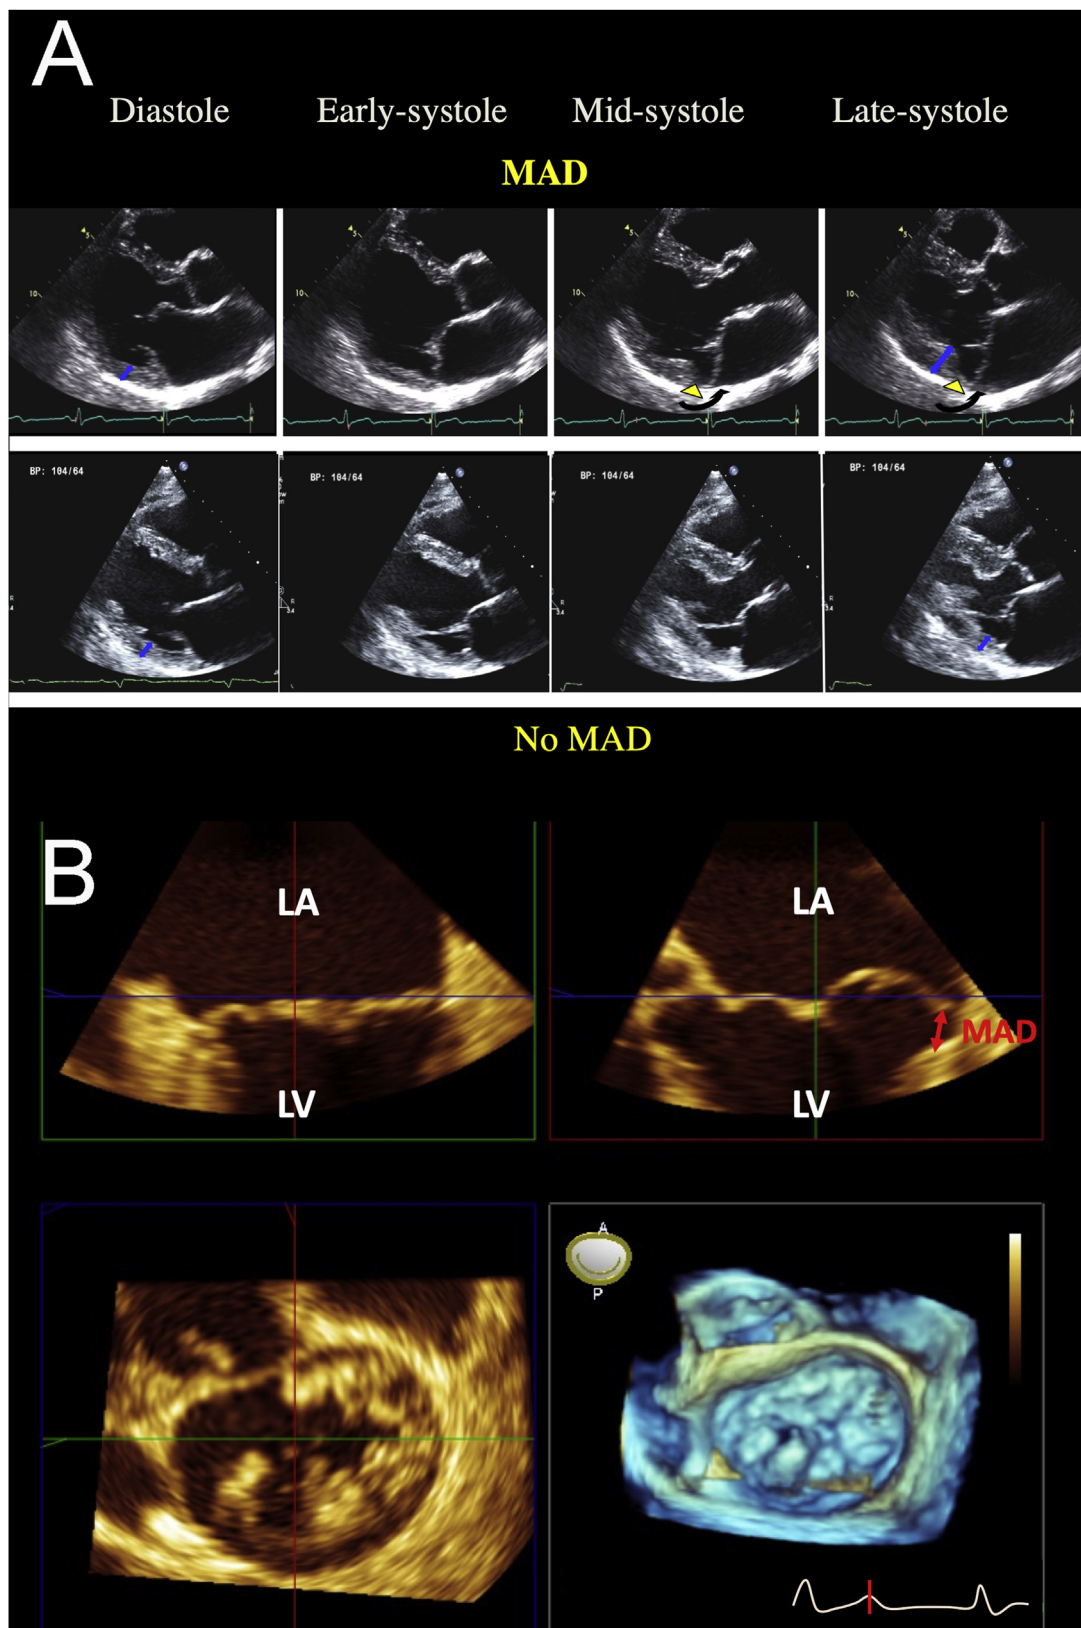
MAD of degenerative MV disease. Two-dimensional transthoracic echocardiographic long-axis dynamic view through the cardiac cycle (A) displaying degenerative MV disease with prolapse and MAD (*yellow triangle*) in systole (*top*) versus no MAD (*bottom*). Note the excess left ventricular PW thickening (*top right, blue arrow*), along with the annular slippage (*top right, black arrow*) with MAD. (B) Three-dimensional intraoperative transesophageal echocardiographic view of degenerative myxomatous valve disease with MAD. LA, Left atrium; LV, left ventricle.
